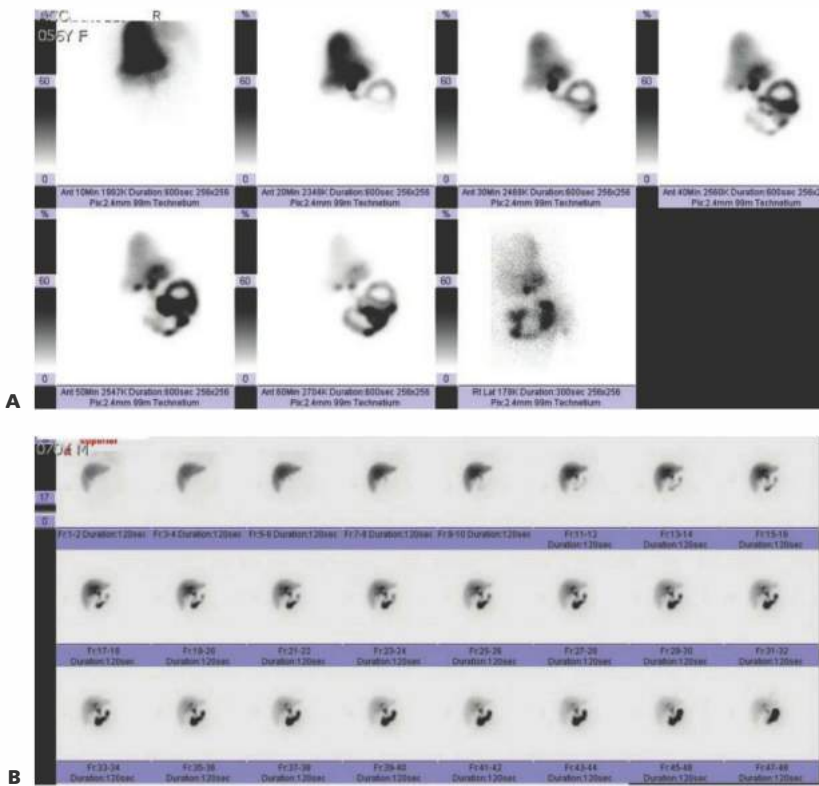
• HIDA scintigraphy. In Figure A, tracer promptly fills the gallbladder and duodenum, demonstrating normal gallbladder physiology and a nonobstructed biliary system. In Figure B, nonfilling of the gallbladder at 1 hour following substrate injection is consistent with acute cholecystitis.
